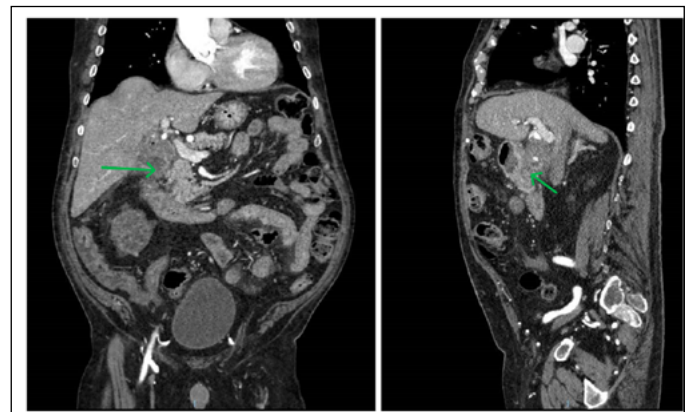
Coronal and sagittal CT scans of the abdomen with initial contrast, showing an 8 mm cholecystoduodenal fistula with rarefaction of fat adjacent to the gallbladder and duodenum.
